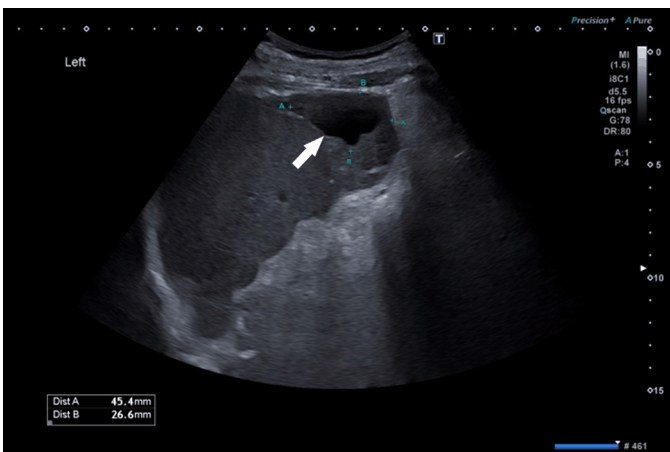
Ultrasound follow up post drainage, showing only a small area of subscapular infarction (white arrow).
